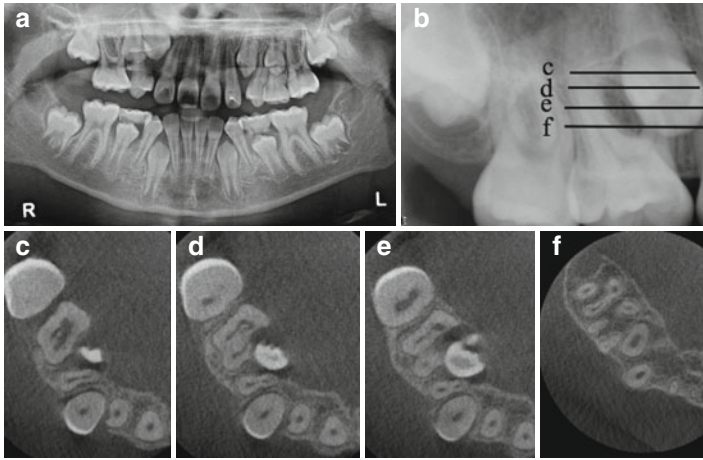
(a) Panoramic radiograph of a 9-year-old patient that was referred to evaluate the path of eruption of tooth number 4 as part of orthodontic treatment planning. (b) Periapical radiograph of tooth number 4. The *lines* on the periapical radiograph correspond to the axial section views *c*, *d*, *e*, and *f*. (c–e) are the different coronal-apical cross section levels demonstrating the ectopic resorption of the mesio-palatal aspect of tooth number 3 by the cusp tip of tooth number 4. The resorptive pattern seen on the CBCT axial images cannot be detected on either the panoramic or periapical radiographs. (f) The most apical cross section showing no resorption at that level
